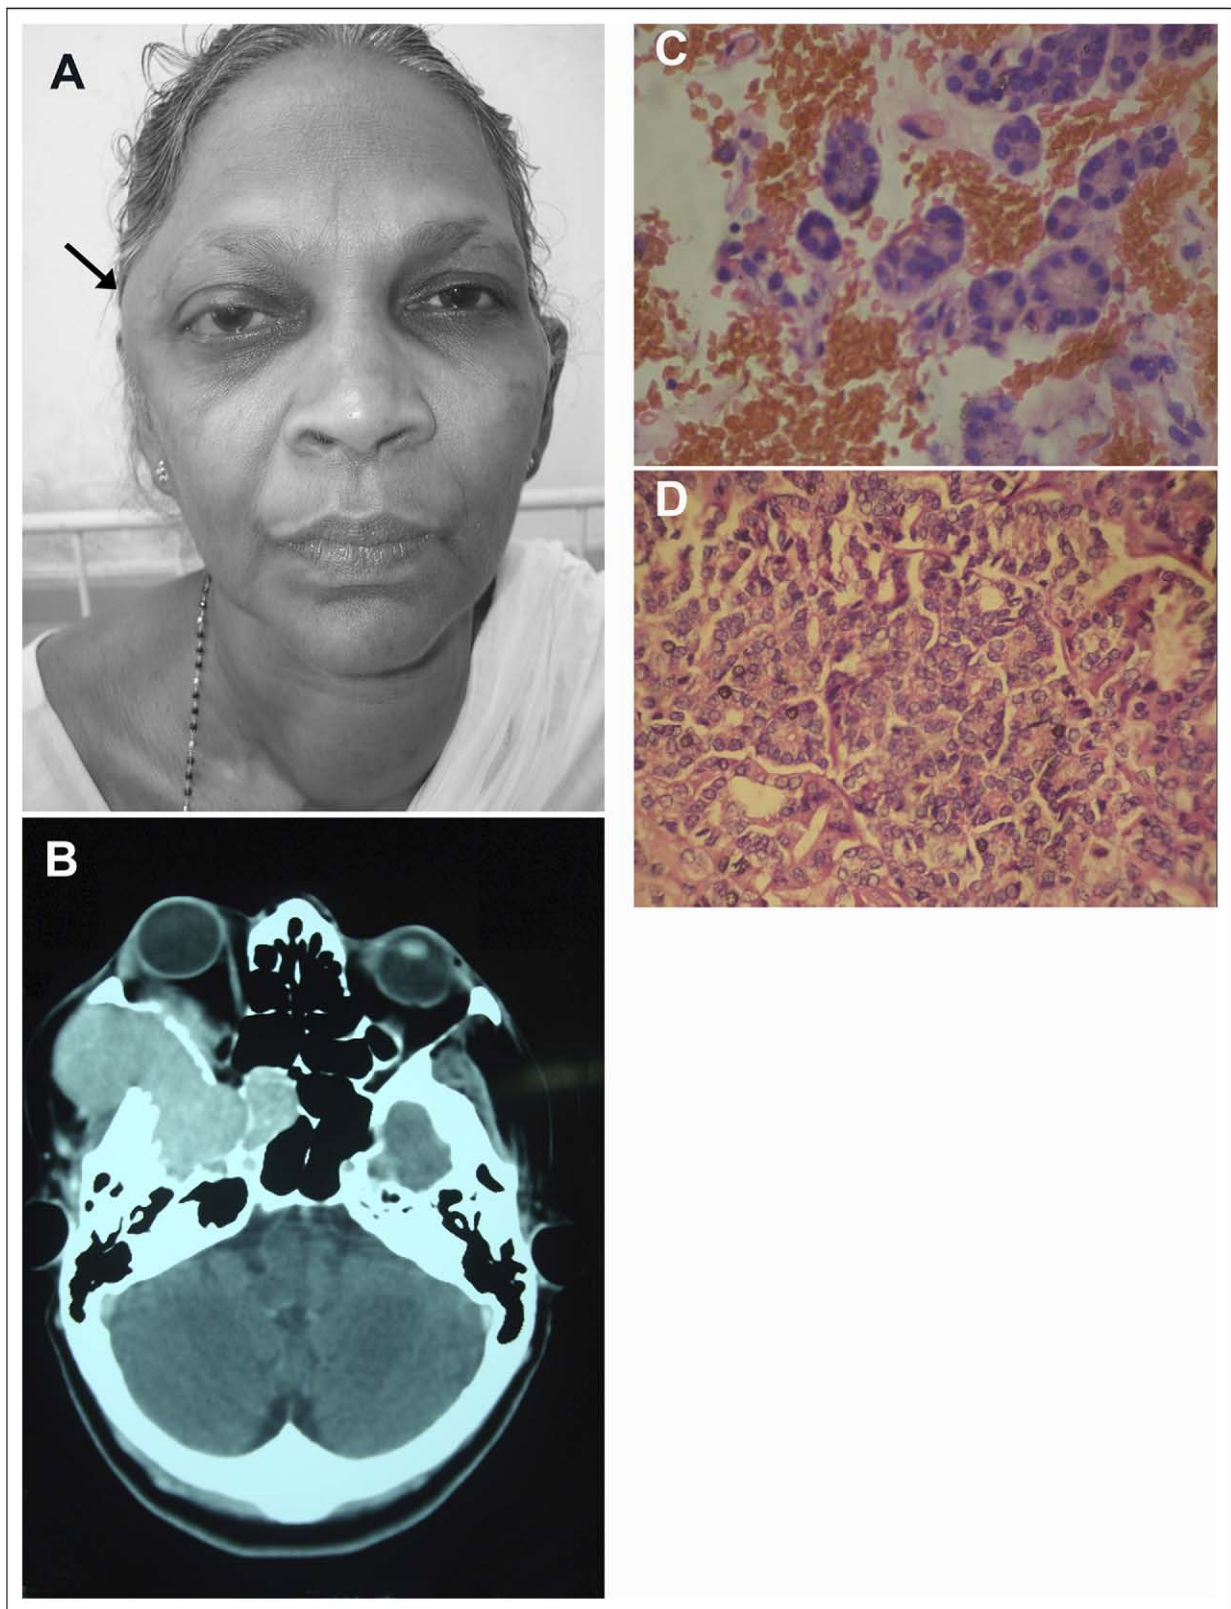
(A) A subcutaneous swelling of 5 cm × 5 cm in the right temporal region. (B) A computed tomography scan of the head showing an isodense-enhancing lesion in the right temporal region with erosion of the temporal bone and greater and lesser wing of sphenoid and intraorbital, intracranial, and subcutaneous extension. (C) Fine-needle aspiration cytology from the subcutaneous swelling on the right temporal region showing follicular neoplasm suggestive of metastatic follicular carcinoma from the thyroid. (D) An excision biopsy of the multinodular goiter showing infiltrating follicular neoplasm composed of cells arranged in follicular, trabecular, and insular pattern separated by thin fibrovascular space. Foci of capsular and vascular invasion are suggestive of poorly differentiated follicular thyroid carcinoma.
